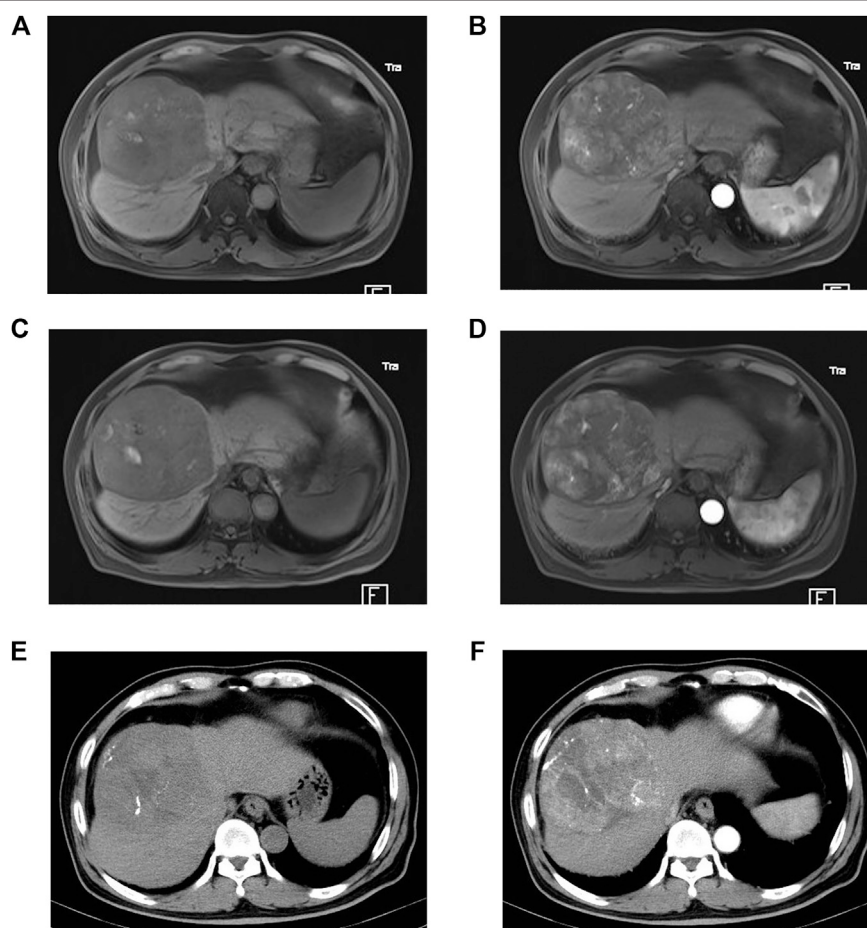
A 69 years old male with hepatocellular carcinoma (HCC) has undergone transarterial chemoembolization (TACE). Early TACE refractoriness is found after two consecutive TACE procedures. The baseline dynamic MR shows an 11 cm tumor with heterogeneous enhancement (A, B). The first follow-up dynamic MR shows a viable tumor >50% (C, D), and the second follow-up dynamic CT also shows a viable tumor >50% (E, F).
